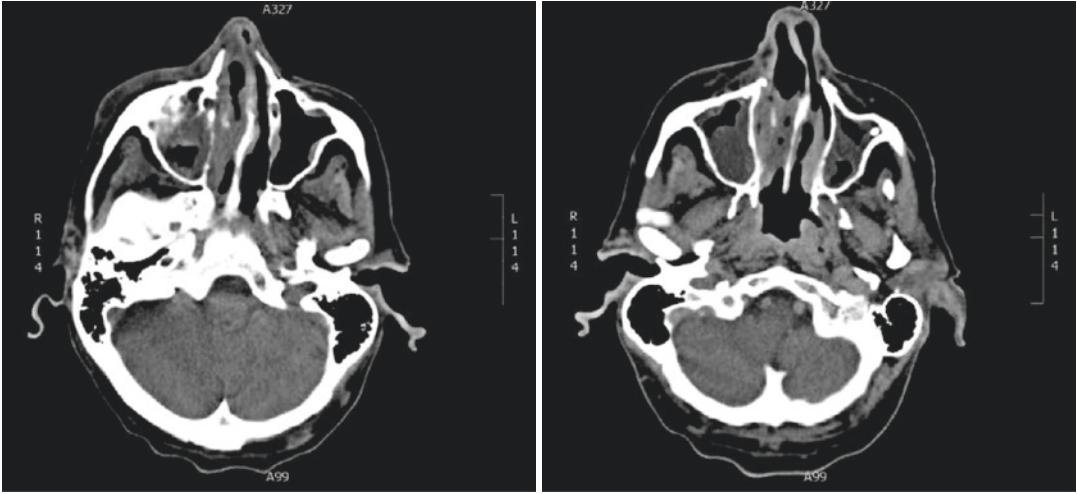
CT scan of the paranasal sinuses
